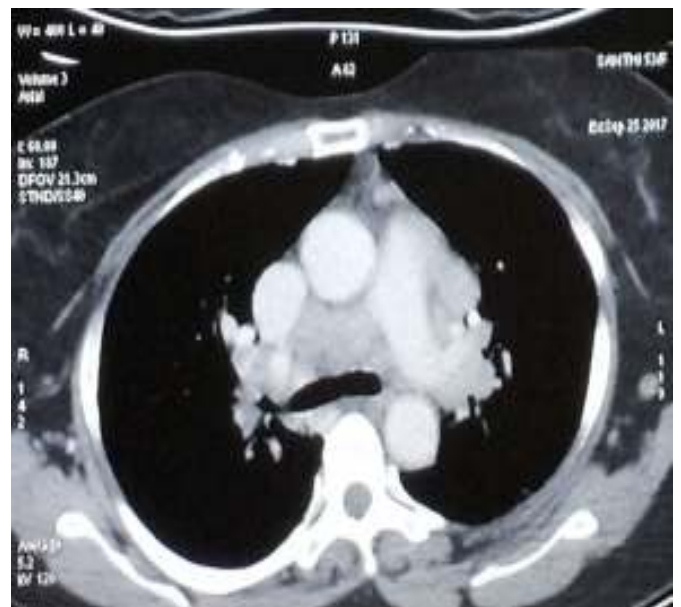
Axial section of Contrast enhanced CT Thorax, mediastinal window showing bilateral subcarinal and hilar lymphadenopathy
